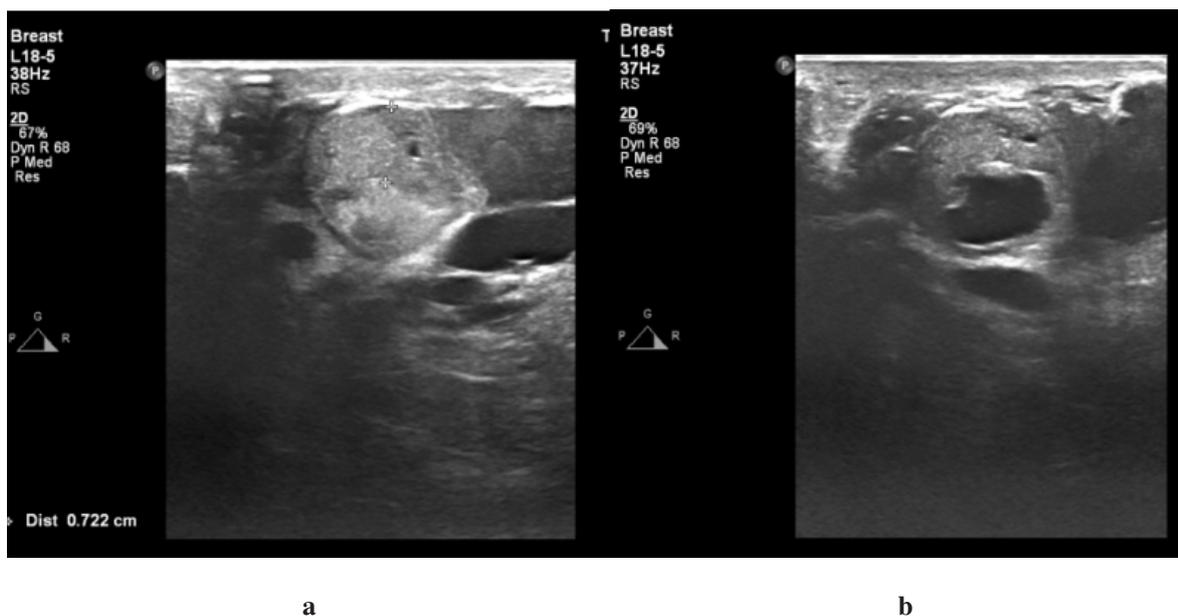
Intraductal papilloma. Ultrasound images reveal a dilated lactiferous duct with a solid mass and blood in different stages of degradation. a. longitudinal section b. transverse section.
